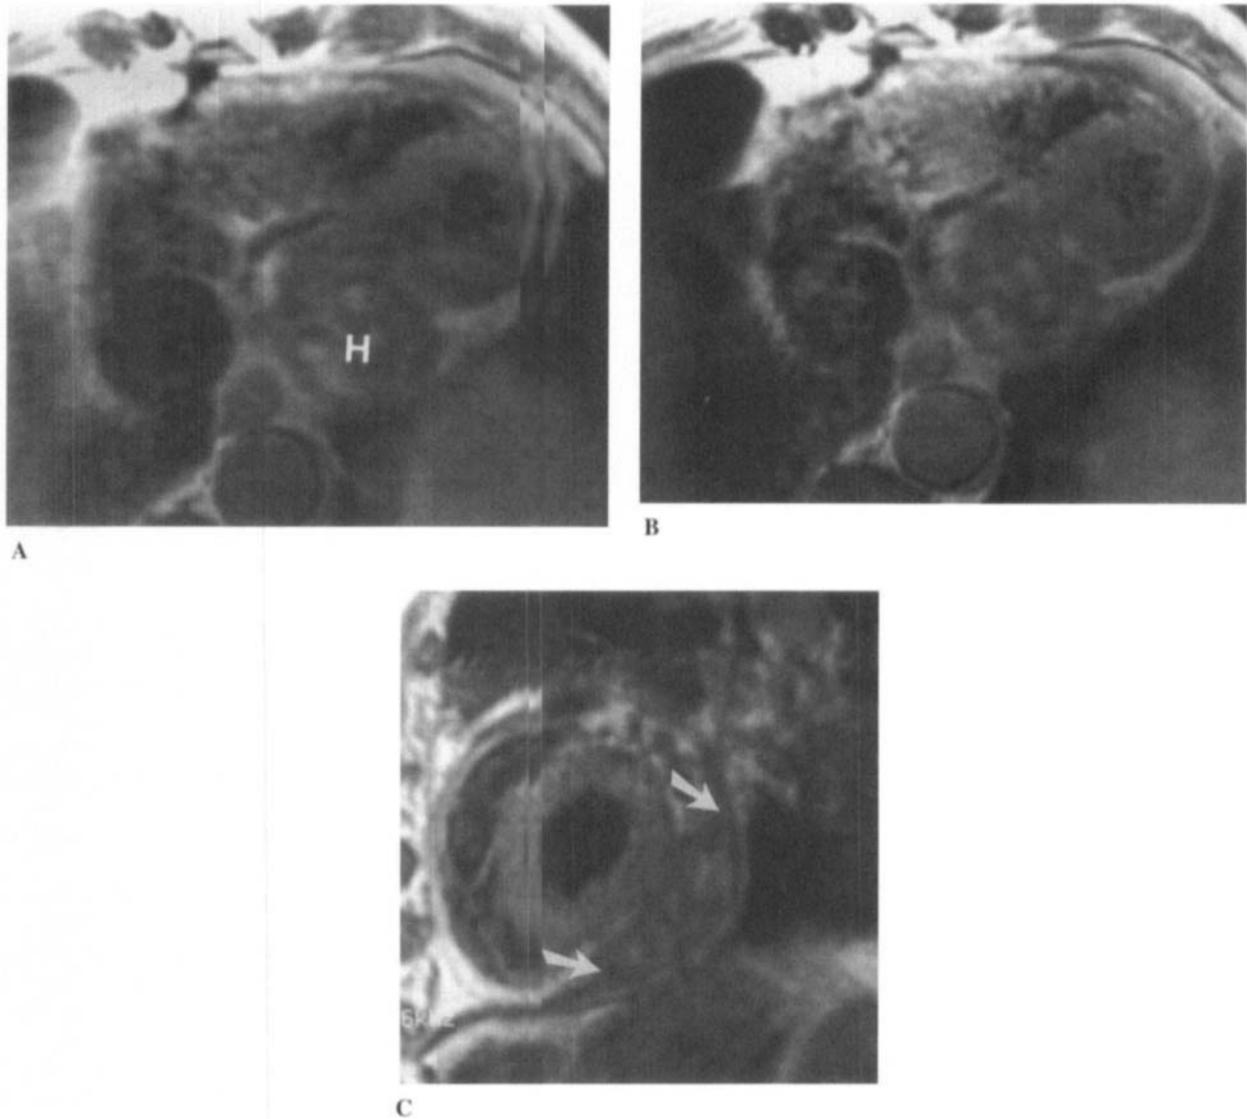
Patient 3: Axial MRI in a 71-year-old man who underwent type A aortic dissection repair 2 years before. Pericardial hematoma (H) is seen in the left atrioventricular groove. (A) Axial SE T1-weighted image (TR 895, TE 20) shows a heterogeneous mass with foci of high signal intensity. (B) Axial SE T1-weighted image (TR 895, TE 20) after administration of Gd-DTPA demonstrates no enhancement of the mass. (C) Sagittal SE T1-weighted image (TR 895, TE 20) confirms the intrapericardial location of the hematoma, which forms acute angles with the pericardium (arrows).
